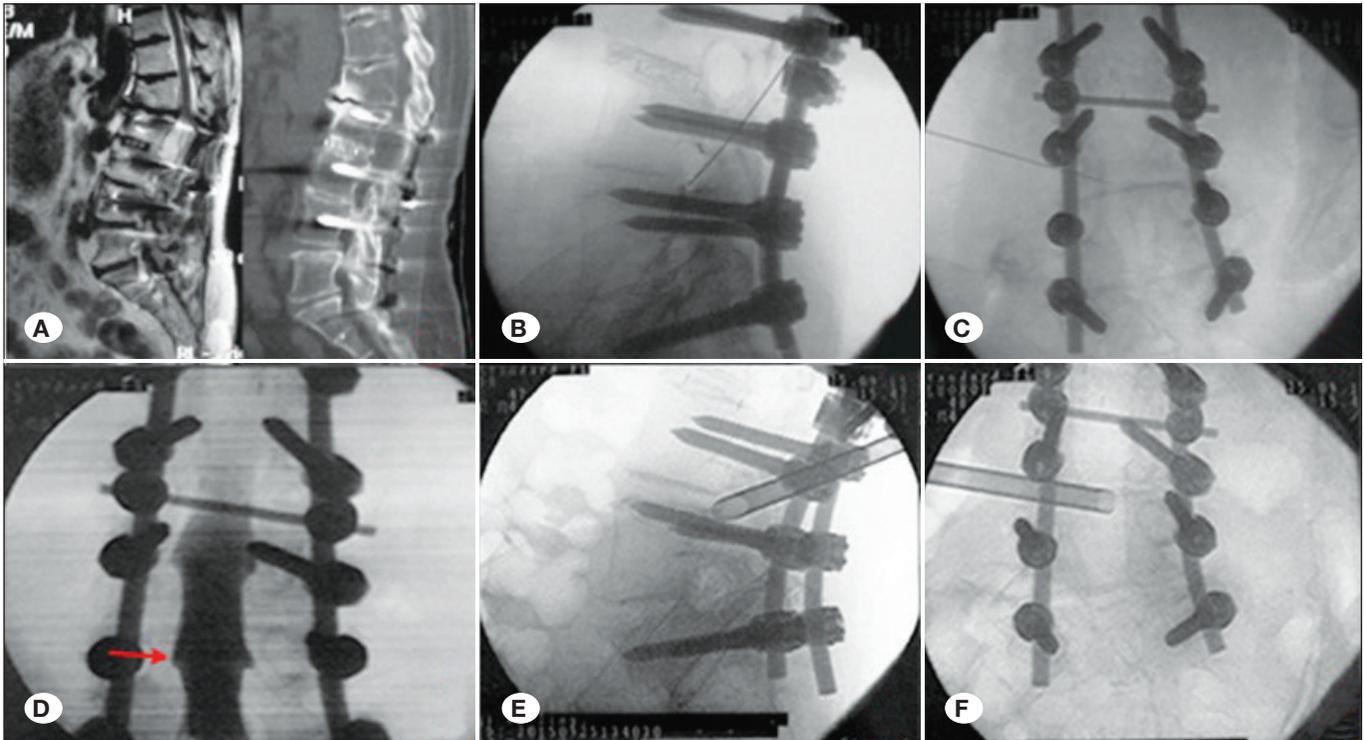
Imaging results for female patient (67 years old) whose radicular pain of the right limb with intermittent claudication occurred immediately after multilevel lumbar fusion. the symptoms were relieved partially after the dissection of partial SAP during the PELs. A) MRI of lumbar fusion surgery of the patient. B, C) Location of needle tip during modified SSNB under lateral and antero-posterior X-rays. D) Myelography revealed compression of the right L5 nerve root (red arrow). E, F) Location of working cannula during PETLS under lateral and antero-posterior X-rays.
